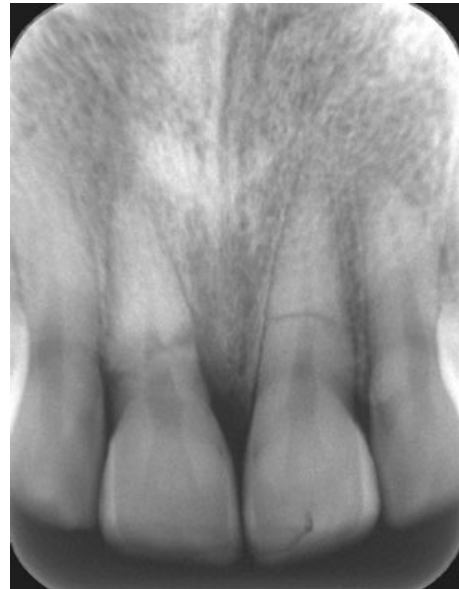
Diagnostic radiograph of the horizontal root fractures of the central incisors. Note the spontaneous healing of the left incisor with calcified tissue radiographically. Moreover, note the loss of the lamina dura around the coronal fragment and periapical radiolucency around the apical fragment in the right incisor.
